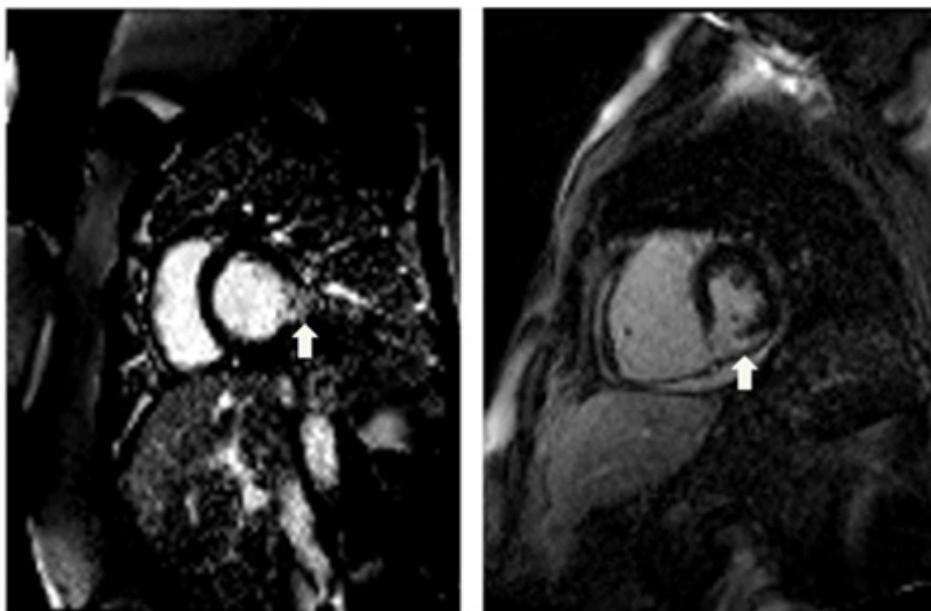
Late gadolinium enhancement-cardiac magnetic resonance images from patients with inferior wall myocardial infarction (white arrows show myocardial fibrosis in the inferior wall).
